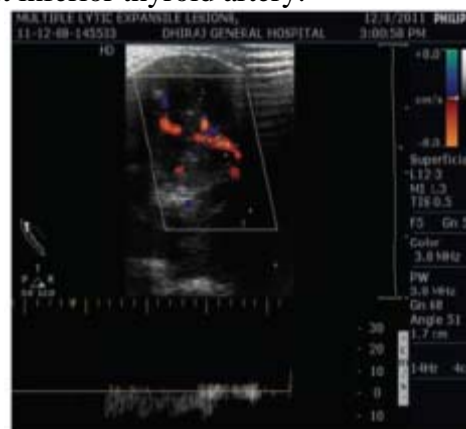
Ultra sonography colored Doppler of neck shows presence of hypoechoic lesion at inferior pole of left thyroid gland.
